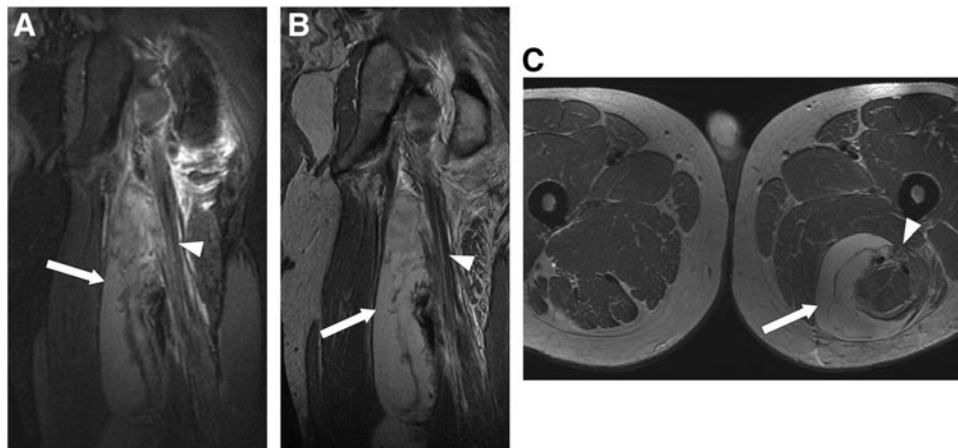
(A) Coronal views of inversion recovery and (B) fast spin echo, as well as (C) axial view of fast spin echo MR images after traumatic injury to the lower extremities reveal the presence of a large hematoma (white arrow) that is responsible for compression of the left sciatic nerve (white arrowheads). Reprinted with permission from Burge *et al.*³⁰ MR, magnetic resonance.
